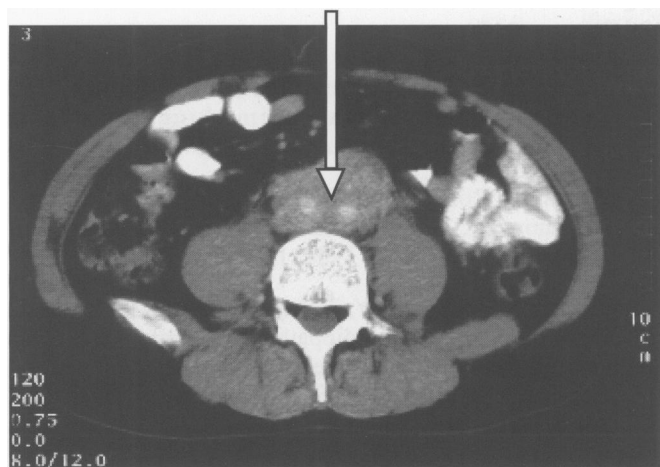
and 2B. CT scans showing significant soft tissue mass with IMA passing through the mass and compressing it.
